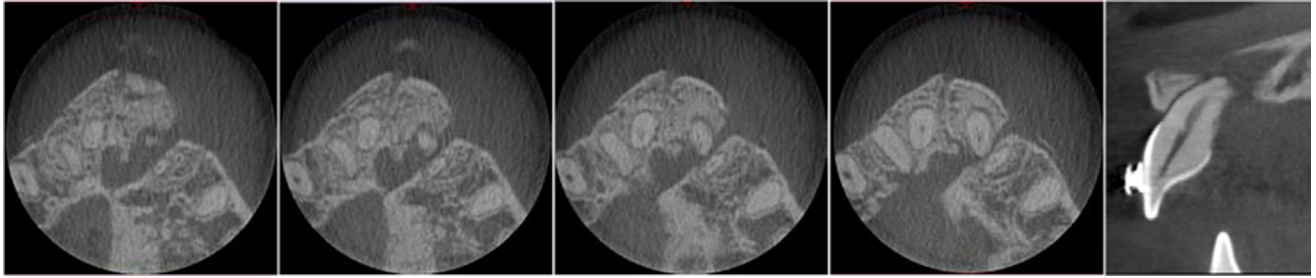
A CBCT radiograph taken when the patient was 16 years old showcasing a large radiolucent bony cleft extending through both the buccal and palatal cortices adjacent to the root apex of tooth #9. This radiograph was taken to assess the anatomy of tooth #9 and the associated periapical radiolucency before the nonsurgical primary endodontic treatment of tooth #9.
